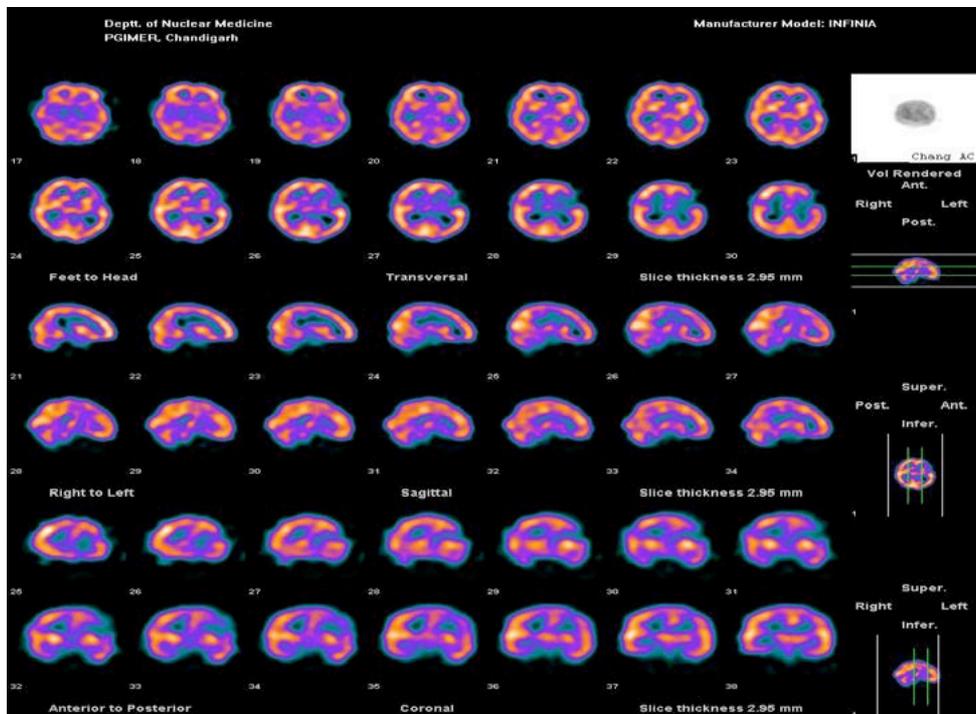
Post-operative SPECT showing severely reduced perfusion in left frontal cortex (mild improvement perfusion in left frontal cortex compared to pre-operative SPECT).
